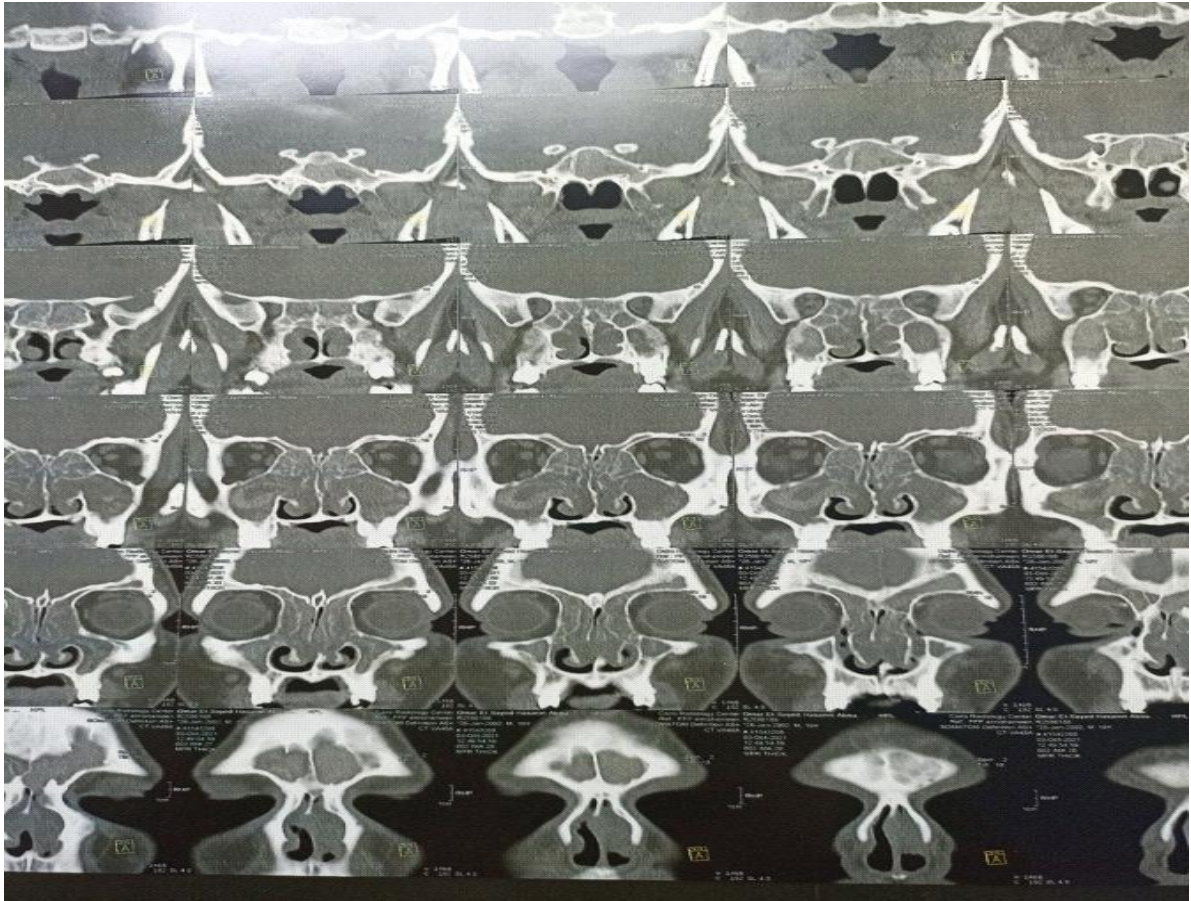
CT Nose & Para nasal sinus show full opacity of sinus
